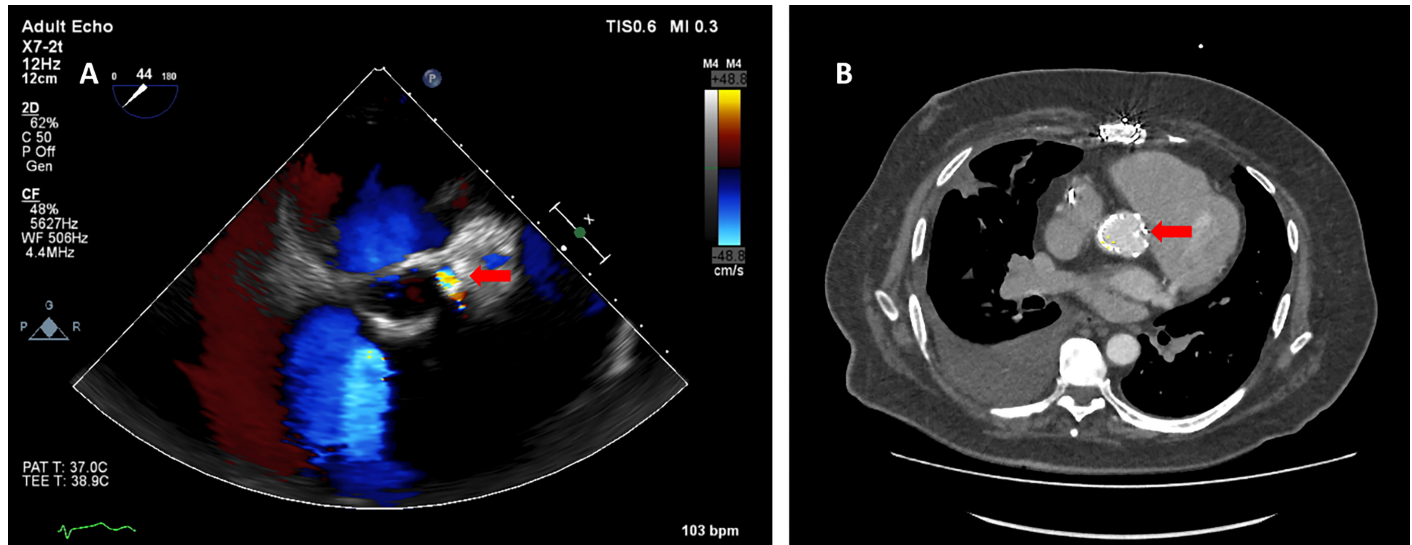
Patient 3. (A) Transthoracic echocardiography showing moderate paravalvular aortic regurgitation. (B) Multidetector computed tomography demonstrating stent infolding and structural deterioration of the Perceval M prosthesis.
